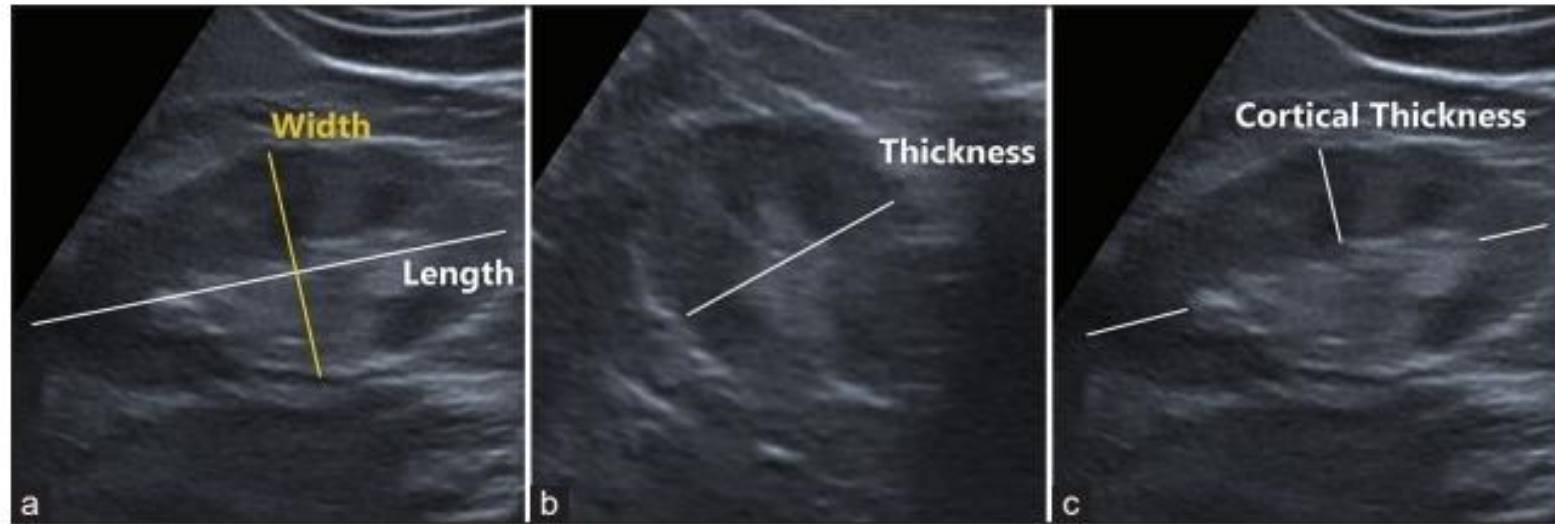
A 60-year-old male patient with chronic kidney disease. (a) Renal ultrasound image indicates the maximum longitudinal length (white) and maximum transverse width (yellow) measured in the coronal plane, (b) maximum thickness (THK) measured in the transverse plane, (c) cortical THK measurements in the ultrasound image from the outer border of the kidney cortex to the outer border of the medulla.
